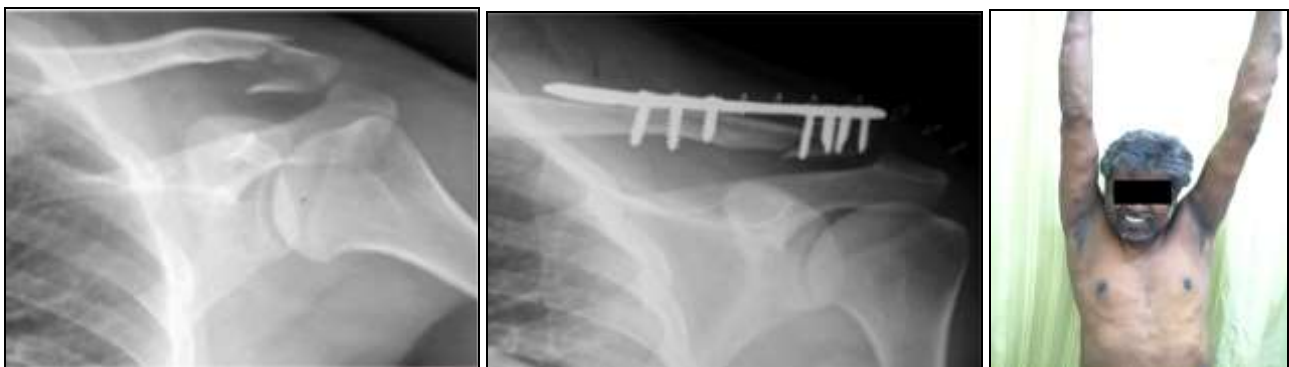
A 50 years old male with left lateral end clavicle fracture, preoperative x-ray and immediate post operative x-ray.
